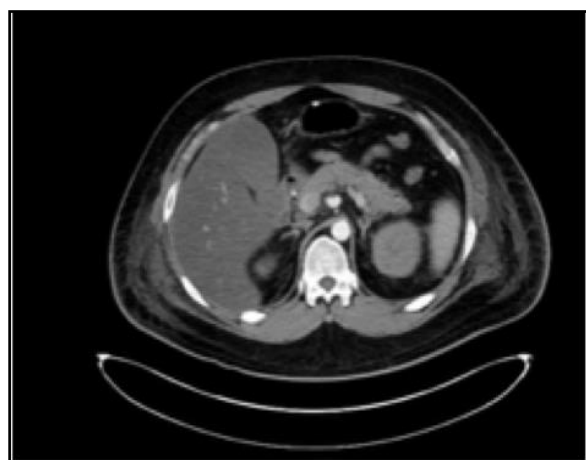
Based on the results of the abdominal computed tomography (CT) scan, there were no signs or evidence of acute pancreatitis
